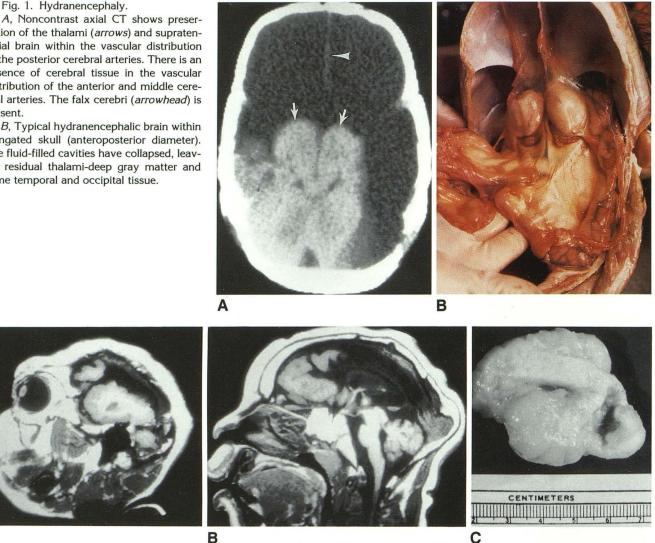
Twin-twin transfusion resulting in in utero H-I event. A, Sagittal T1-weighted image shows severe microcephaly.
